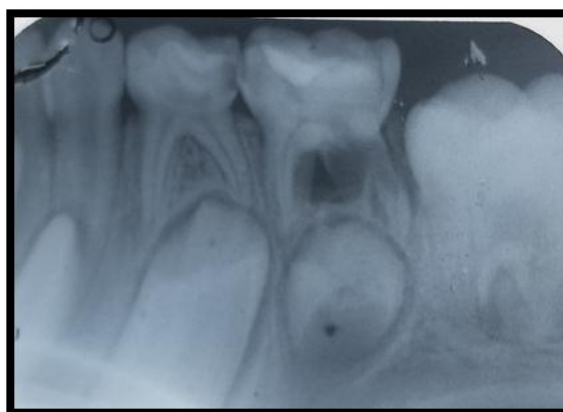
Radiographic Examination W.R.T 74, 75.
